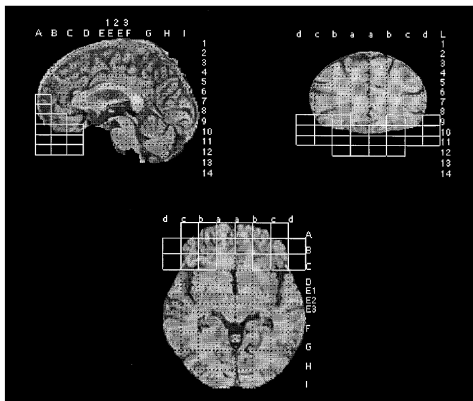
Multiplanar view of a 3D MRI volume within the Talairach stereotactic grid. The boxes drawn in white represent the orbital prefrontal region.
